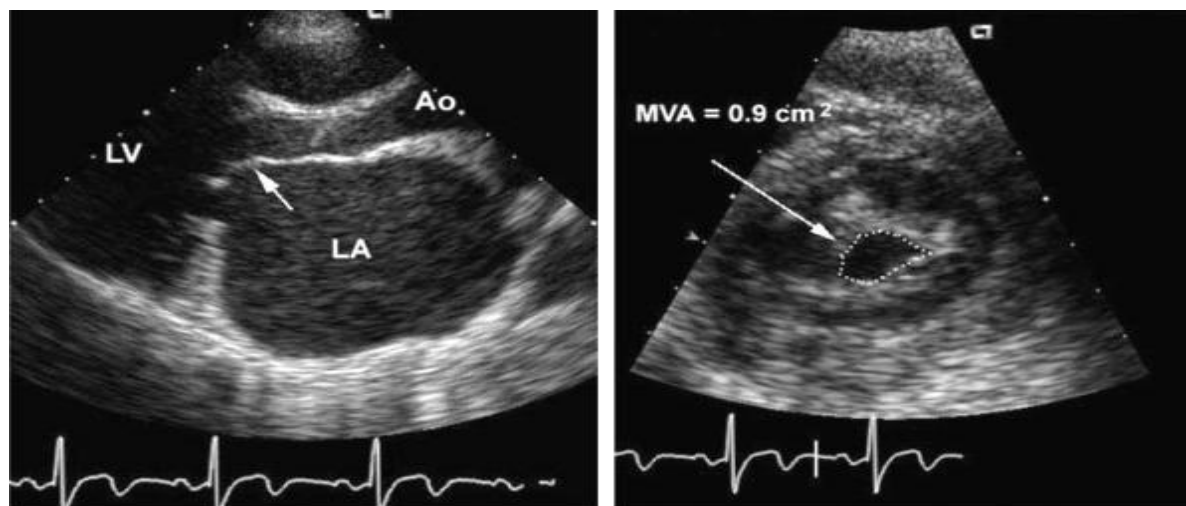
Parasternal long (left) and short (right) 2D echocardiographic views showing the characteristic findings in rheumatic mitral stenosis. Note the commissural fusion that results in doming of the leaflets in the long axis
